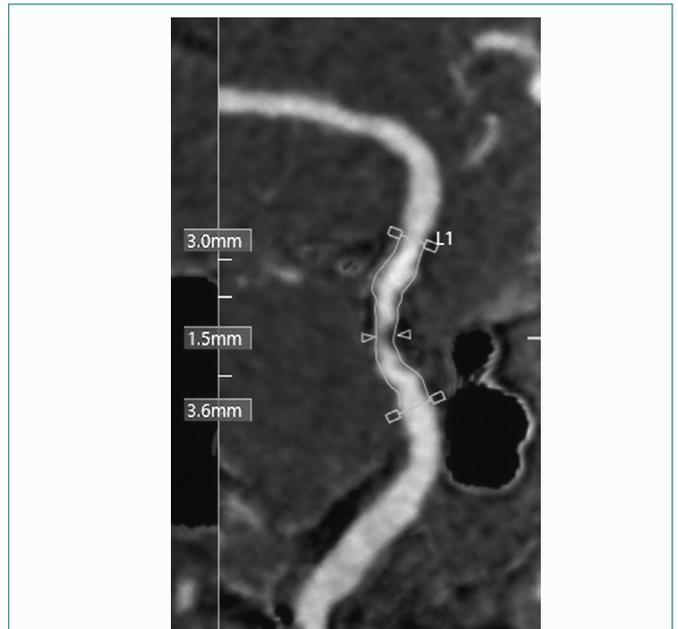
A CTA scan presenting a dissection of the cavernous segment of the right internal carotid artery. Note the luminal size measured in millimeters.
